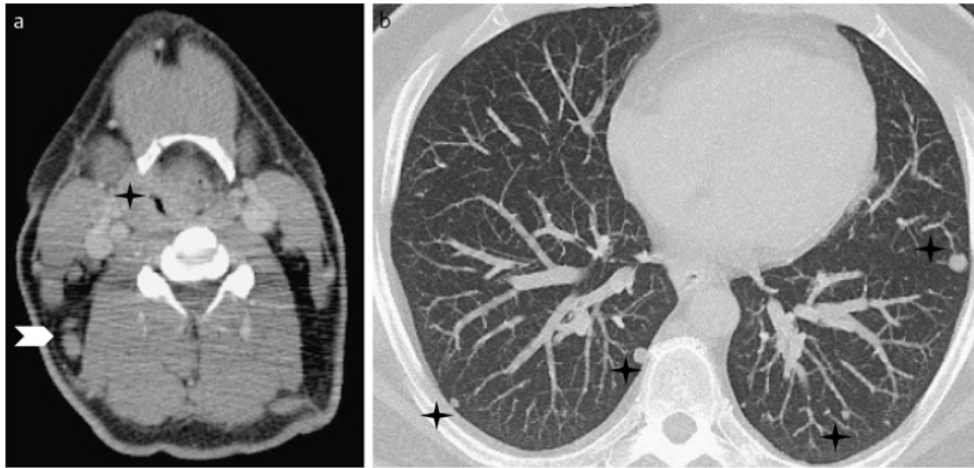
43-year-old male with T4N2cM1 right sided supraglottic laryngeal cancer (Fig. 1a on the left, black star) and ipsilateral lymph node metastases in the right cervical level III (Fig. 1a on the left, white arrow). The pulmonary window setting in the axial CT MIP demonstrates at least 4 metastases in segment 6 of both pulmonary lobes (Fig. 1b on the right side, black stars).
